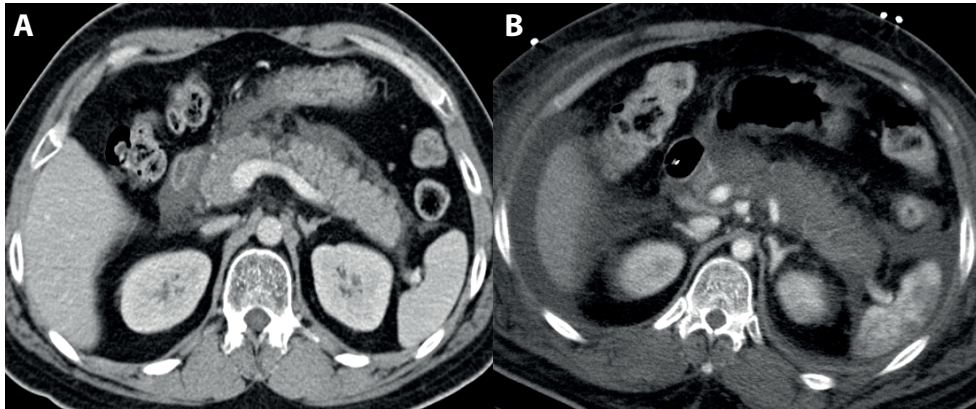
False-negative pancreatic necrosis on early CT. (A) CT performed on the day of admission shows a normal enhancing pancreatic parenchyma with little surrounding peripancreatic fluid. (B) Follow-up CT on day 3 reveals nonenhancement of pancreatic body and tail, indicating pancreatic necrosis.
